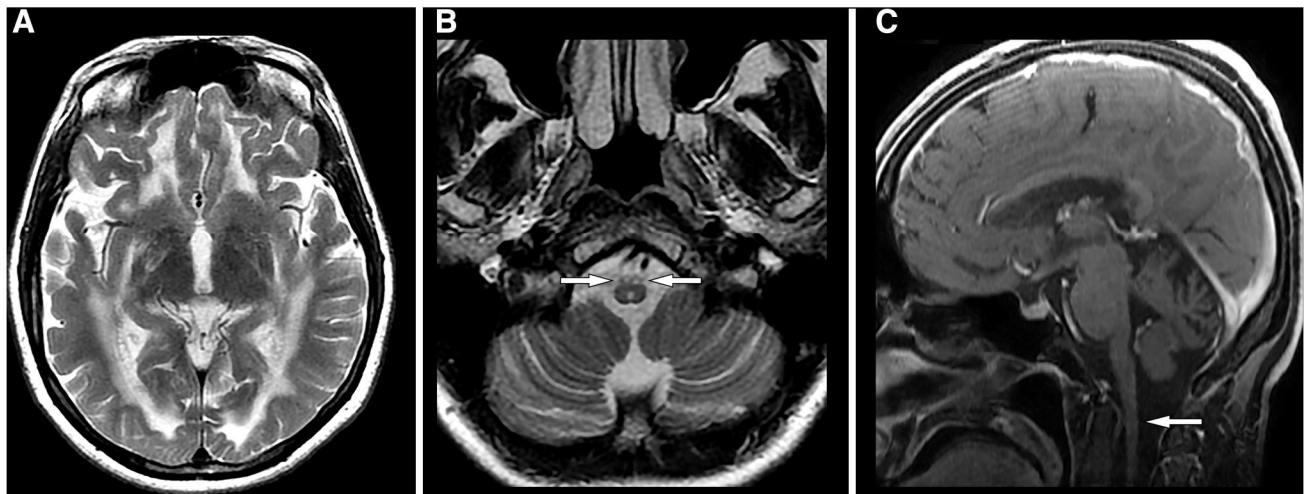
Axial T2-weighted images (a, b) demonstrate symmetric periventricular hyperintensity in periventricular white matter (a) and hyperintensity in both corticospinal tracts (arrows in b). Sagittal
